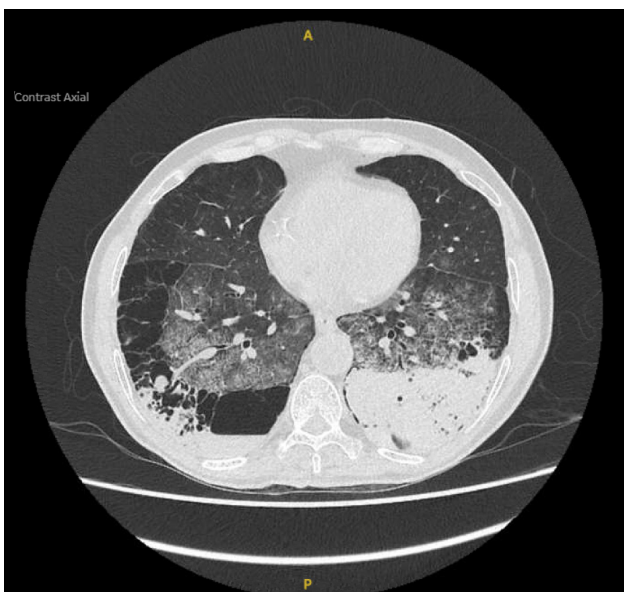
A chest CT showing bilateral emphysemas and signs indicating diffuse alveolar haemorrhage.
